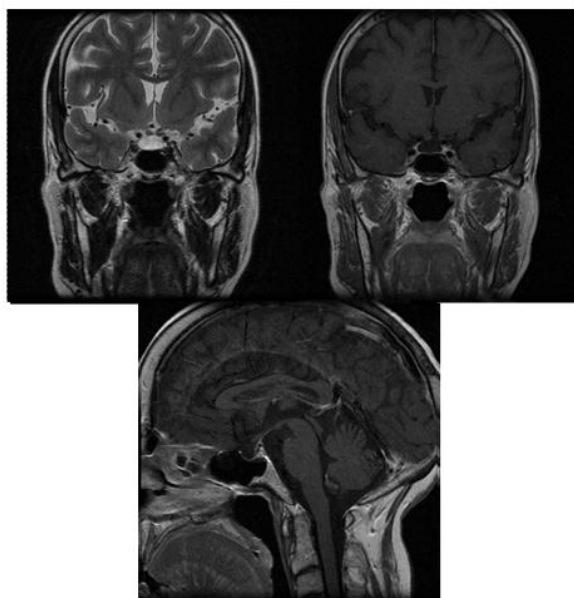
MRI scan showing an empty sella turcica
